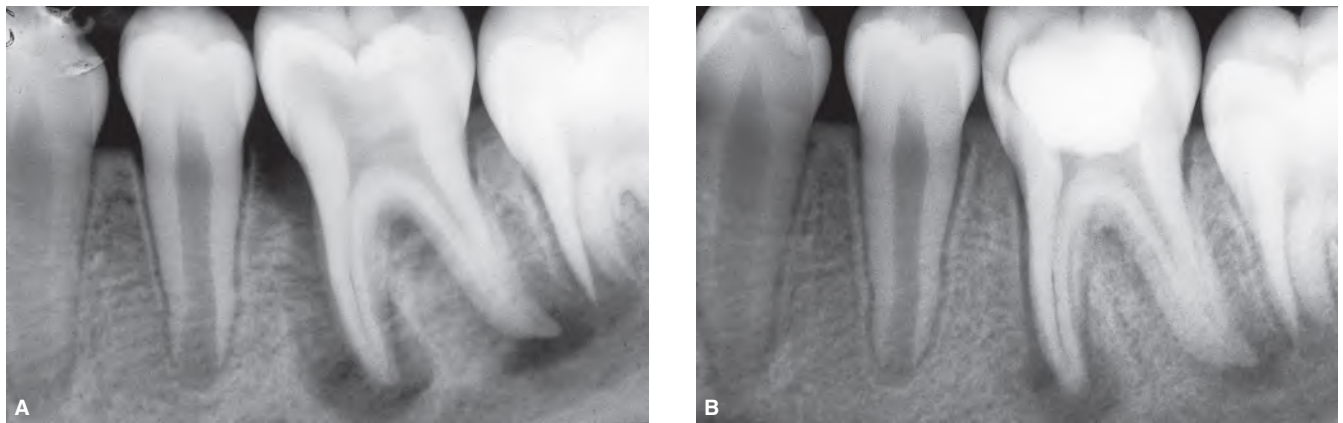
A. Preoperative radiograph of a mandibular left first molar. B. Radiograph taken two months later. The gap in treatment was due to negligence on part of young patient. Four canals had been cleaned, shaped, and medicated with Cresatin. Note the reduction in the periapical radiolucency in spite of the canals not been obturated.
